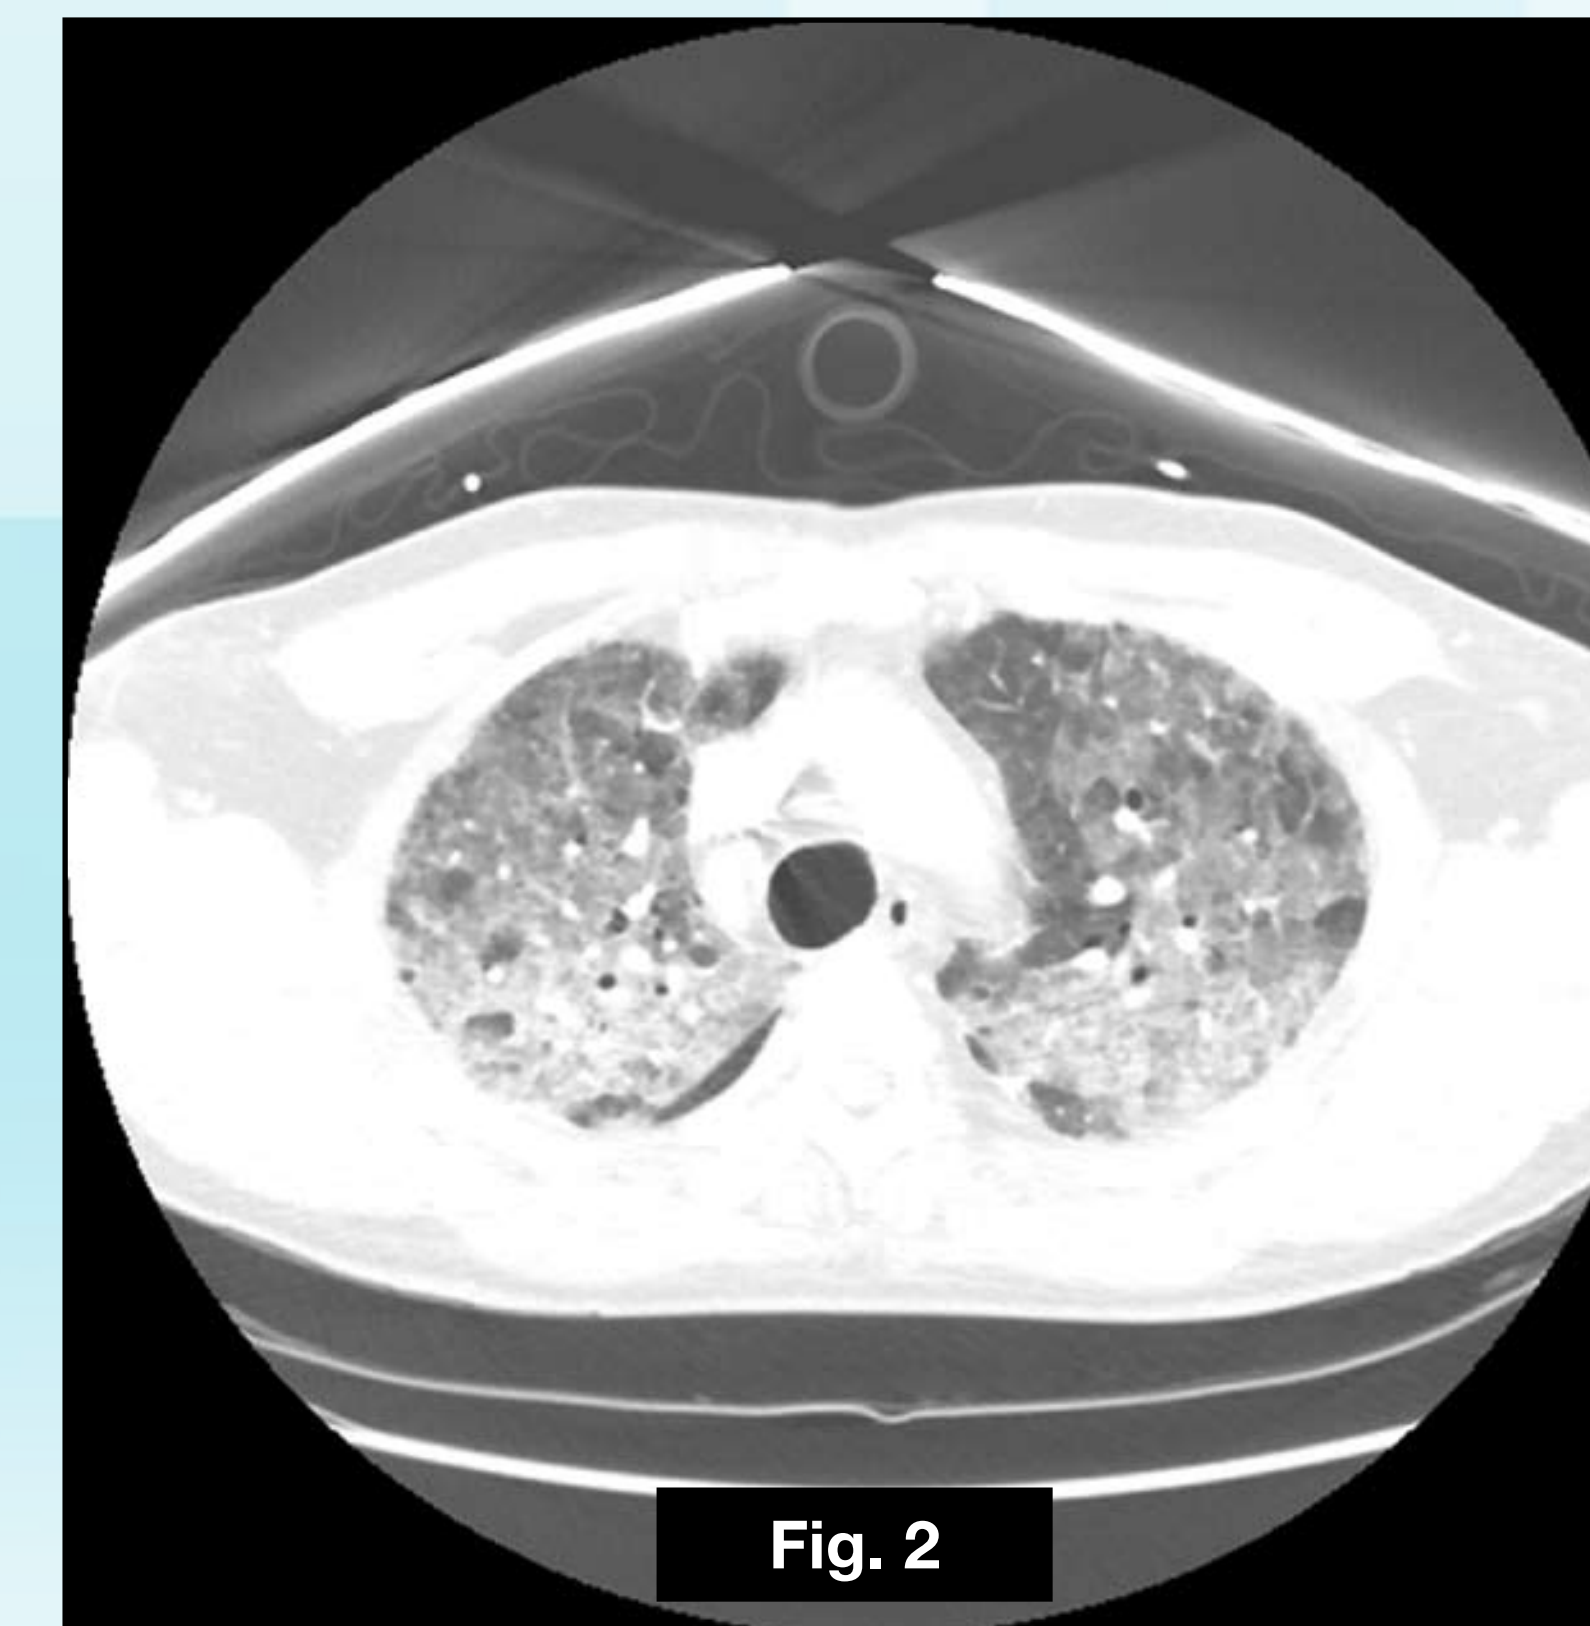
Initial CT of Chest showing bilateral ground-glass opacities.
